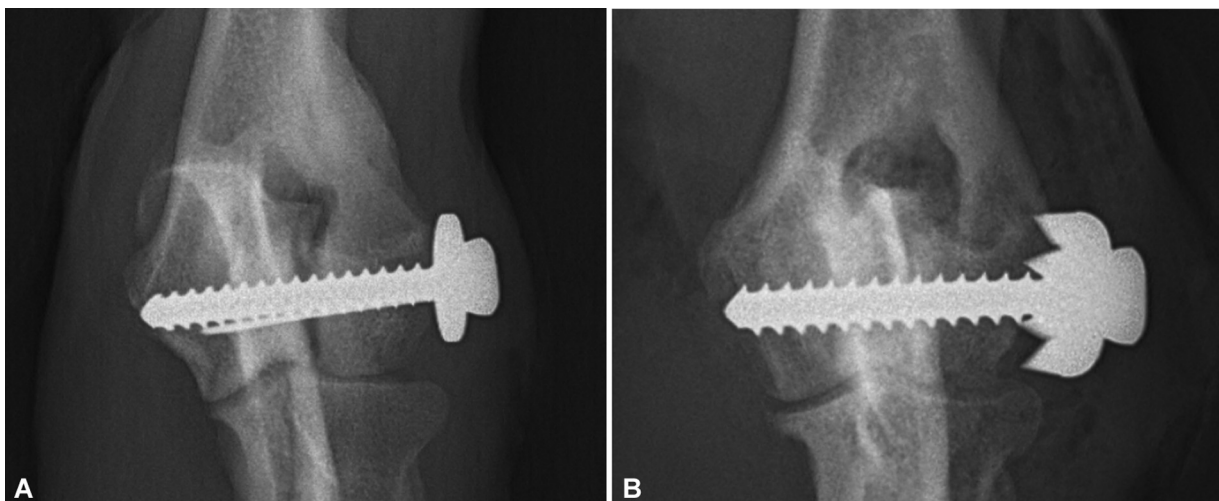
Craniocaudal postoperative radiographs of cases 1 and 2. (A) is the postoperative radiograph of case 1 shows a flat washer and transcondylar Kirschner wire added to the transcondylar screw. (B) is the postoperative radiograph of case 2 shows a spiked washer added to the transcondylar screw.
